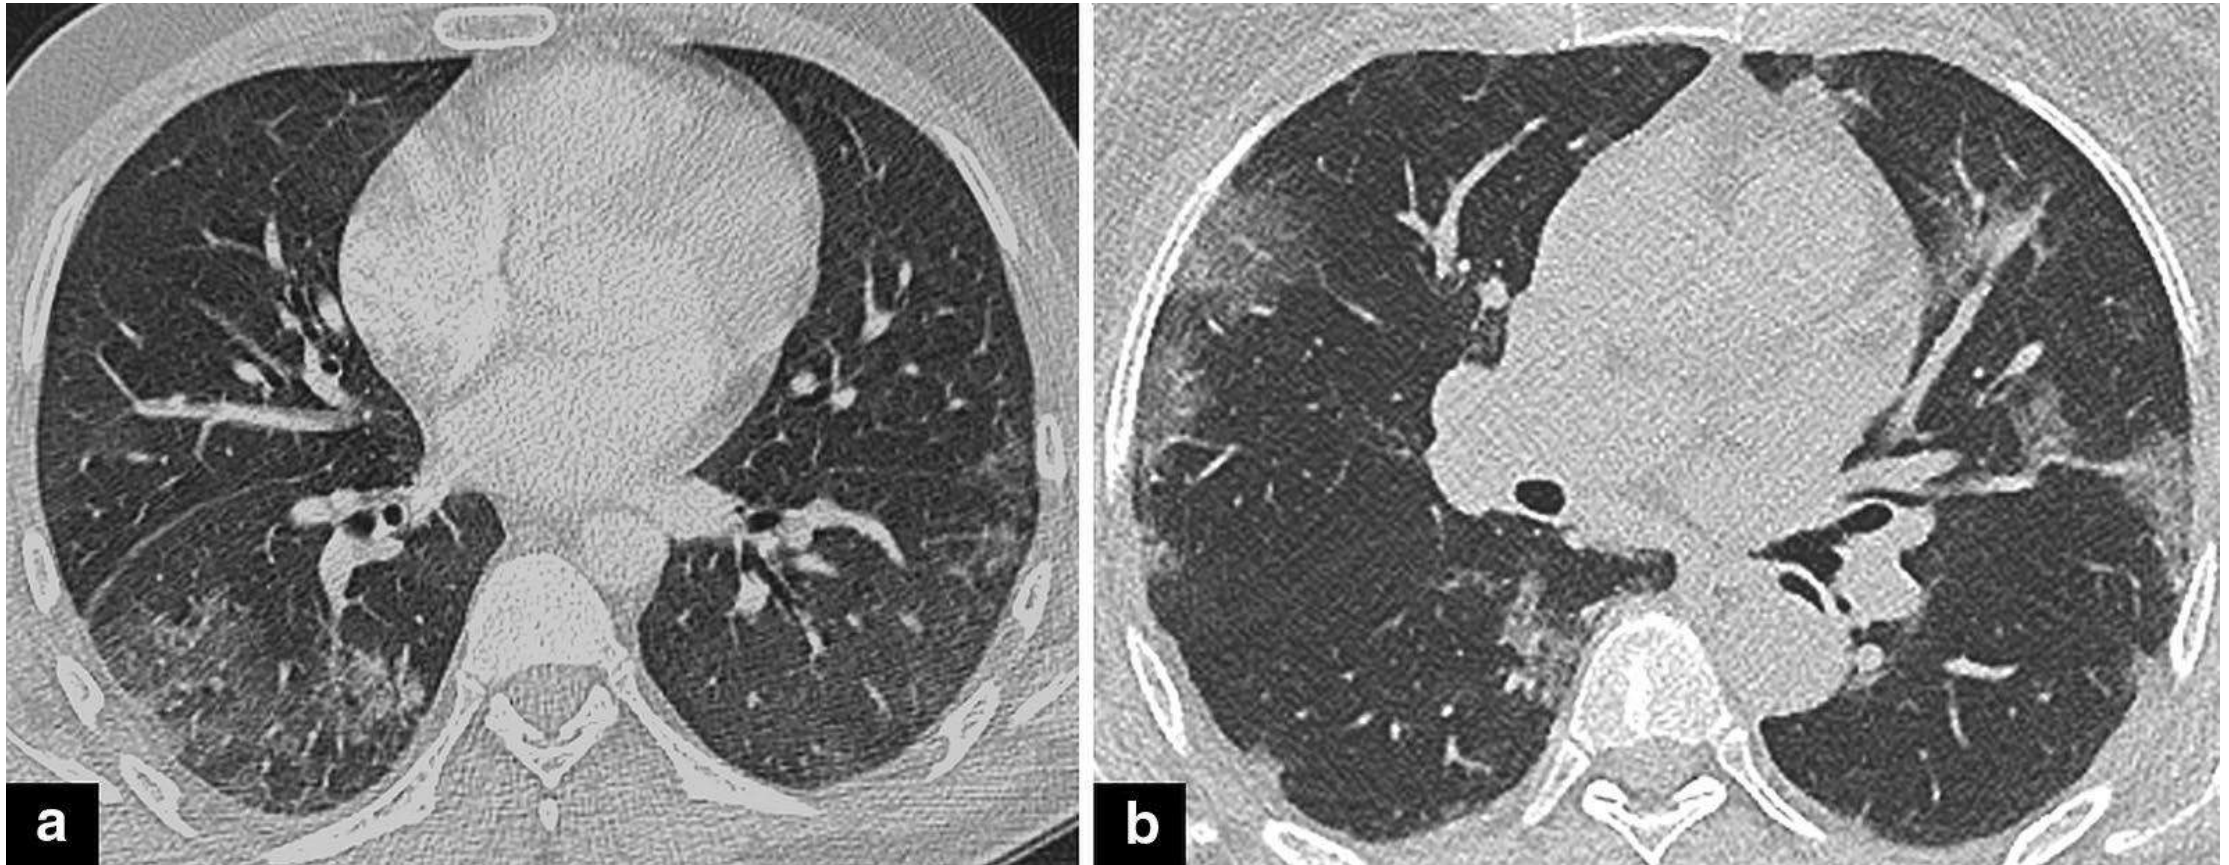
a–b Axial HRCT images of two different patients with diffuse alveolar hemorrhage show bilateral, diffuse hazy groundglass (a–b) and centrilobular opacities (black circle in a) with subtle sub-pleural sparing and a prevalent middle/lower lung zones distribution or “batwing” appearance
